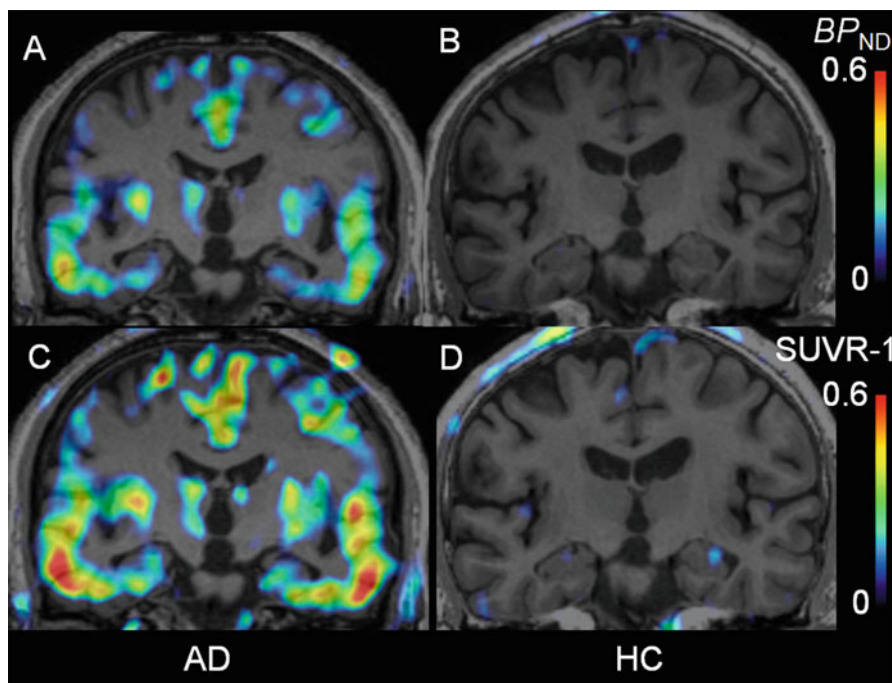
Coronal parametric images of AD and HC. The MRTM_O BP_{ND}^* images in ADs (a) and HCs (b). SUVR-1 images (50 min–70 min) in ADs (c) and HCs (d)
